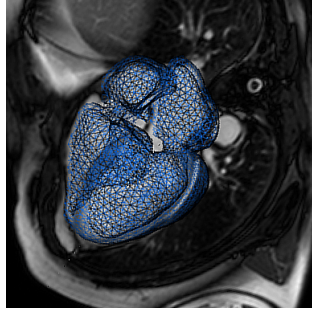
3D SSFP slice with the static mesh resulting from segmentation (animation is then computed from the 4D cine MRI images)
